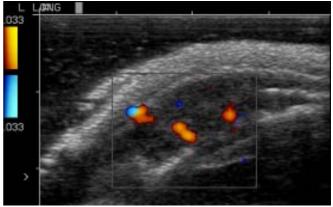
Scattered vascularity with colour Doppler
